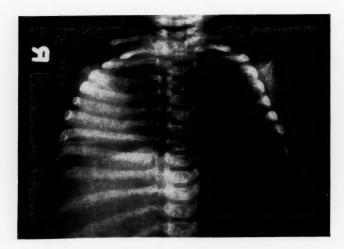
Roentgenogram made on date of admission showing the mediastinal structures displaced far to the right and a dense shadow in the lower portion of the right chest.
